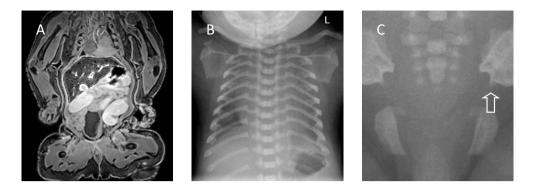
A neonate, born at 41 weeks gestational age, who died shortly after birth. Antenatal US showed an underdeveloped thorax and short stature (T2-W 3-D, slice thickness: 1 mm, TR: 4000, TE: 80). Figure 4b. Chest radiograph shows a severely constricted thoracic cage, underdeveloped scapulae and flattened vertebrae. Figure 4c. Radiograph of the pelvis shows hypoplastic iliac wings and sciatic notch spurs (arrow). Based on the conventional radiological findings, the diagnosis thanatophoric dysplasia type II is most likely (OMIM #187601).
